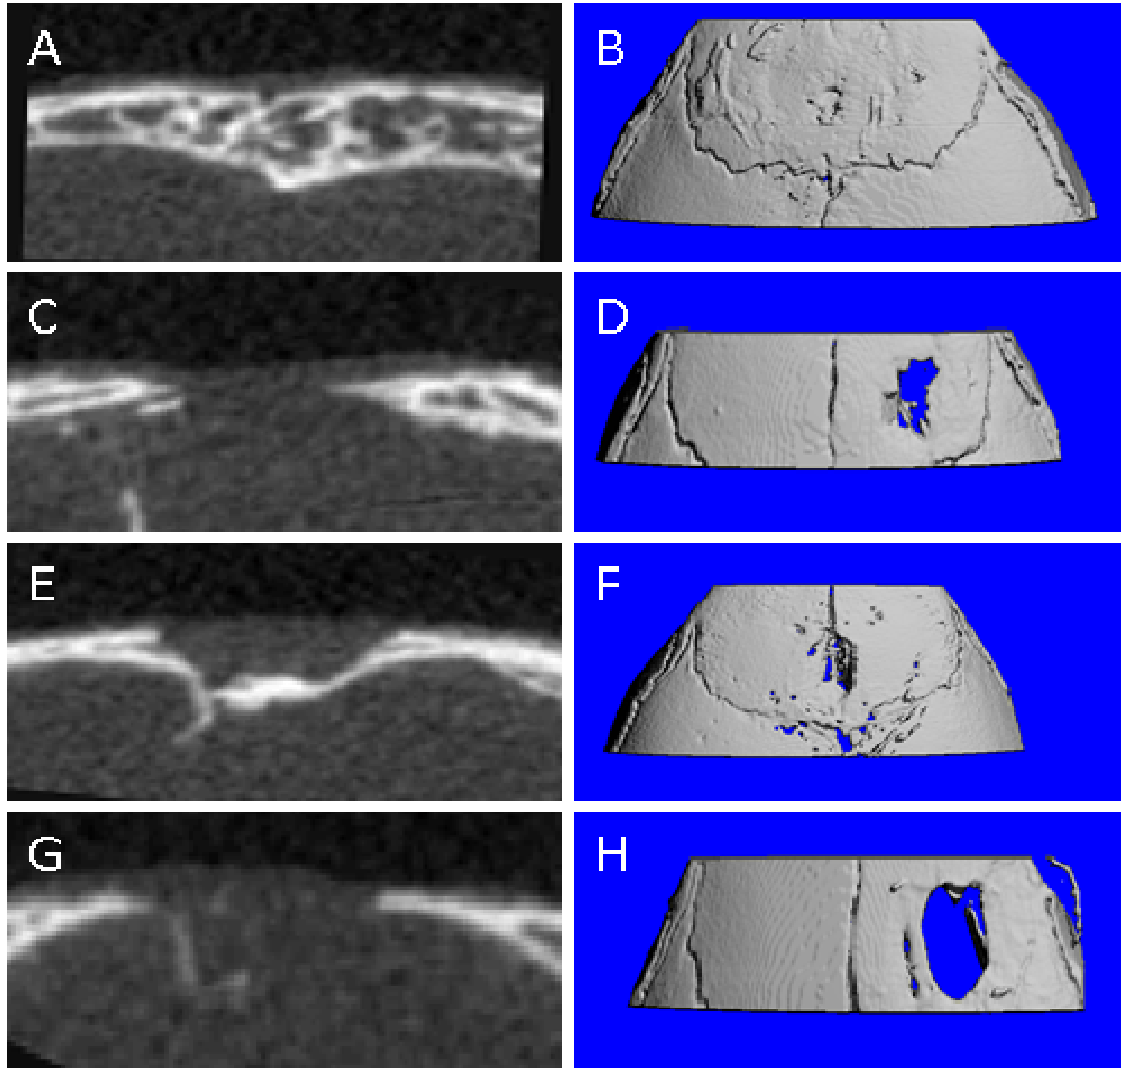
Representative 2D and 3D  $\mu$ CT images for the age and location defects on day 14 post-op. The infant posterior frontal defect shows complete bridging and an increase in the thickness of the bones (A-B). The infant lateral defect shows an increase in the thickness of the edges of the bones in the defect but no bridging (C-D). Adolescent posterior frontal defect shows thin discontinuous bridging along the endocranial surface of the defect, but no increase in the thickness of the bone in the defect (E-F). The adolescent lateral defect shows no increase in the thickness or bridging of bone in the defects (G-H).
